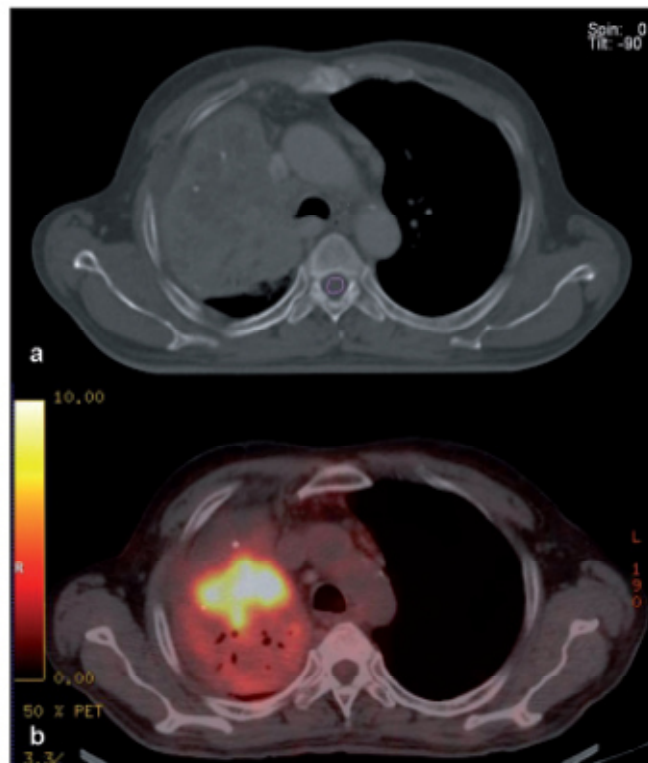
Images from a patient with lung cancer. The axial CT scan (a) showed a large mass in the upper lobe of the left lung. The corresponding FDG-PET/CT image (b) revealed an increased uptake only in the central portion of the mass, representing viable tumour with adjacent areas of atelectasis that clearly lack FDG-avidity (28).
